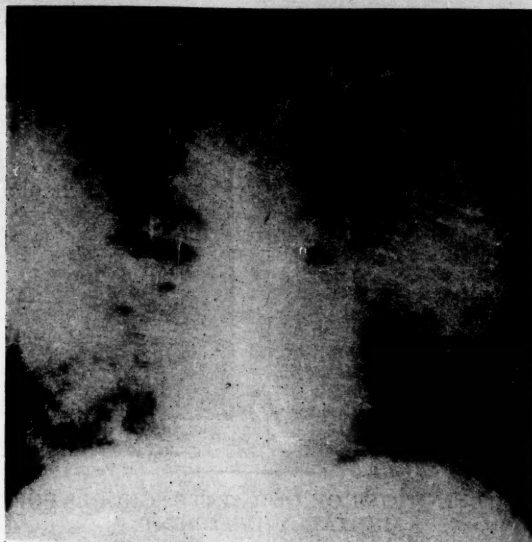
Terminal stage pneumoconiosis. First thought to be very advanced tuberculosis from x-ray.
